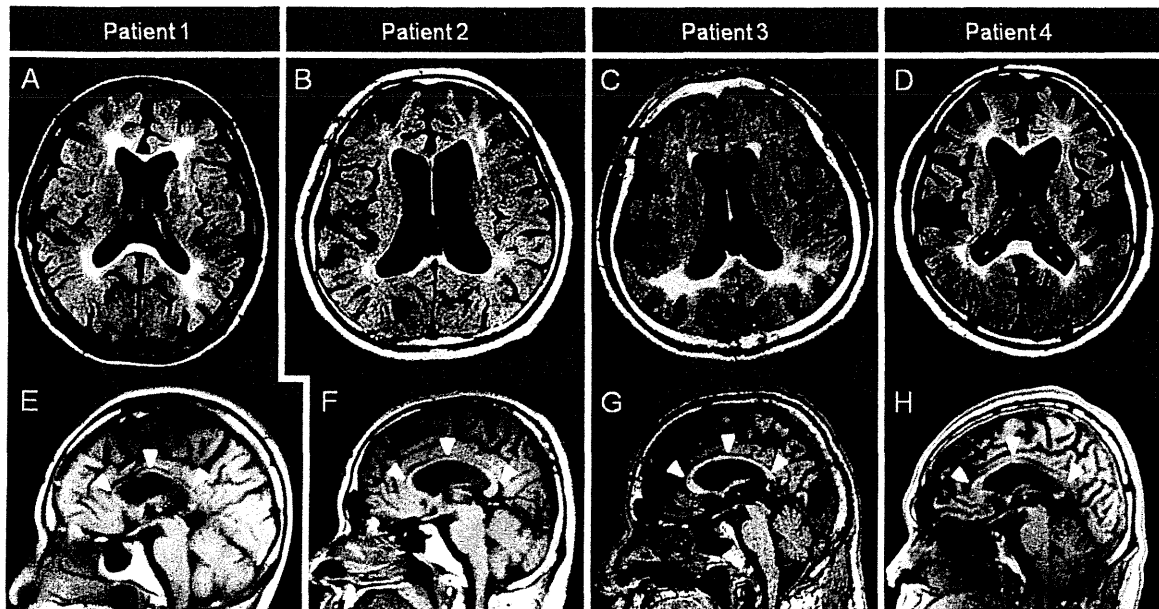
Representative MRI findings of four HDLS patients. A-D: Axial FLAIR images showing patchy or confluent periventricular-dominant white matter lesions and hyperintensity signals in the CC, especially in the splenium. E-H: Midsagittal T1-weighted images showing severe diffuse CC atrophy (arrowheads). (A and E: Patient 1 at age 52 (approximately 19 months after onset); B and F: Patient 2 at age 41 (approximately 11 months after onset); C and G: Patient 3 at age 56 (approximately three years after onset); D and H: Patient 4 at age 42 (approximately 14 months after onset), each patient number corresponding to that in Tables 1 and 2).
